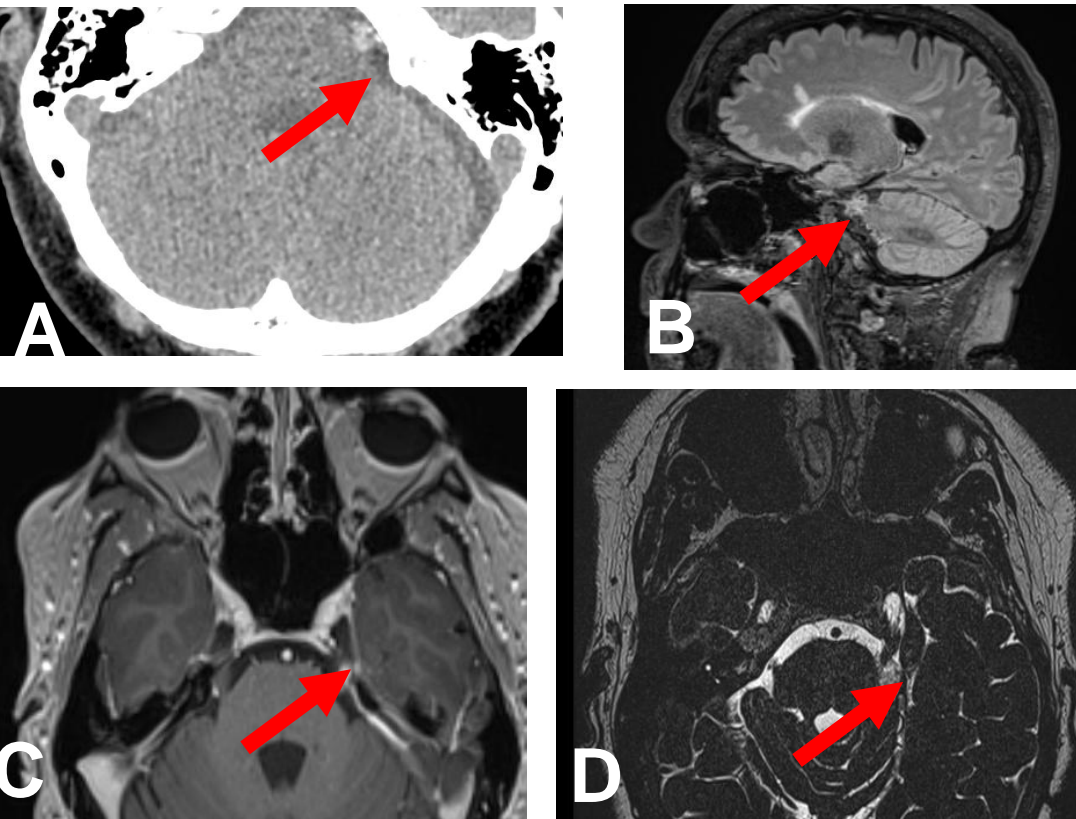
A-D, A axial CT, B Sag FLAIR, C axial post gadolinium T1, D axial thin section T2, red arrow Teflon placed for trigeminal neuralgia formed a "Teflon granuloma" cisternal left trigeminal nerve. Teflon granulomas are hot on PET-CT
